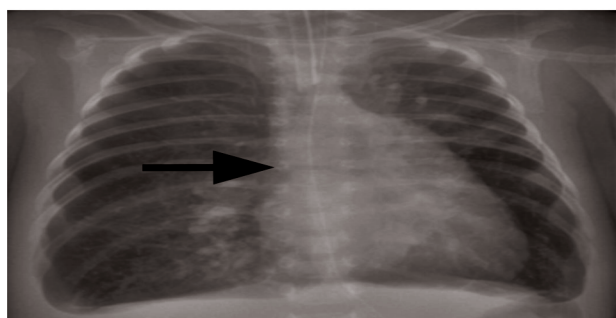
An anteroposterior chest radiograph revealed a low-shaped T carina (black arrow), suggestive of a pseudo carina at the T7-T8 vertebral level, accompanied by horizontally branching bronchi
